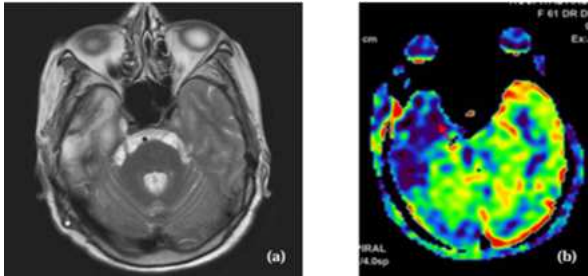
Cerebritis with evolving brain abscess (a) Axial T2-WI shows an ill defined lesion with a high-signal intensity and extensive peripheral vasogenic edema in the right temporal region. (b) ASL MRI showing blue hue in the region indicating hypoperfusion (red arrow).
